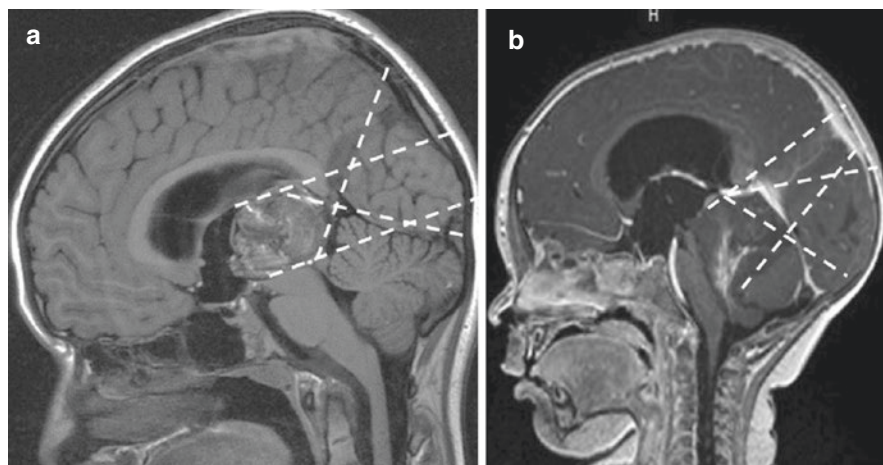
Sagittal postcontrast MR images of pineal region tumor, a posterior III ventricle NGGCT (left) and a ATRT of the superior medullary velum extending from the quadrigeminal cistern to the IV ventricle and cisterna magna (right). Dotted lines show sagittal surgical trajectories to the superior and inferior aspects of the tumor through occipital transtentorial approach
